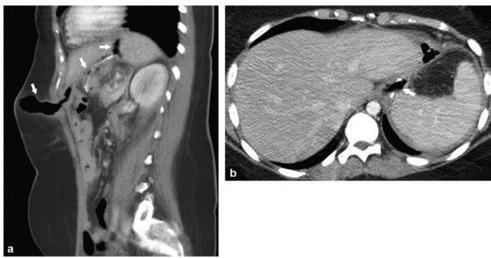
Gastro-cutaneous fistula. a: Gas bubbles (white arrow) can be seen extending from the gastro-cutaneous fistula in the upper part of the staple line on a sagittal CT of the abdomen taken following laparoscopic surgery for the gastrointestinal tract. b: This fistula was caused by a significant leak at the top of the staple line, as shown on axial CT (11).
